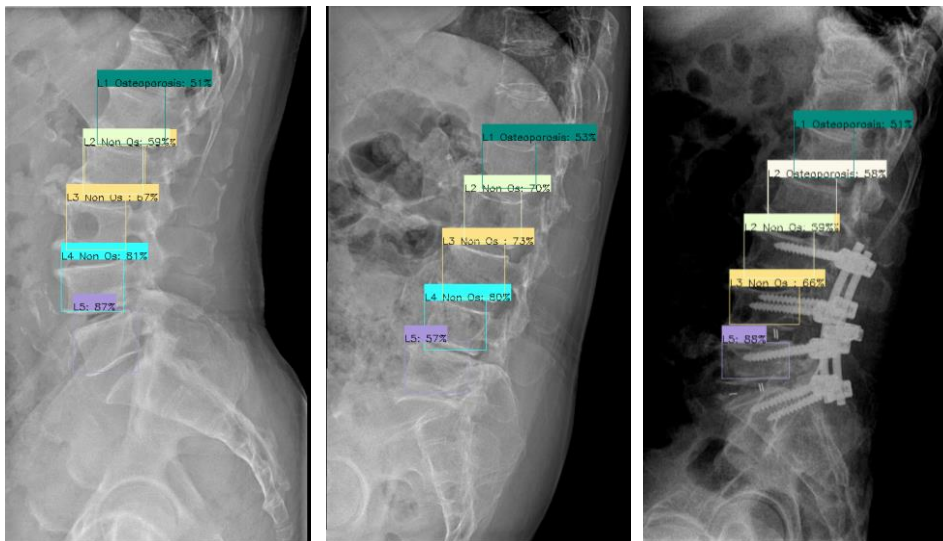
Results of vertebral body detection by RetinaNet-500 with the AP-loss model with X-rays of patients who had undergone various surgeries or procedures.
